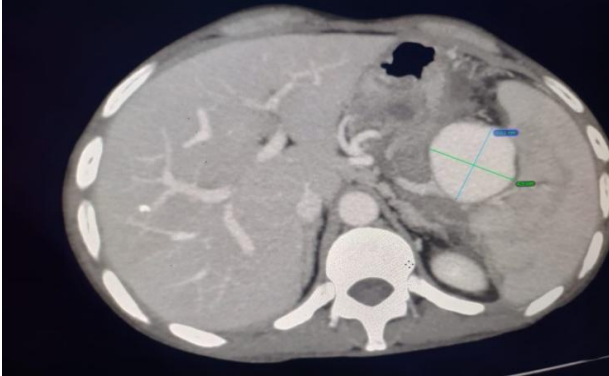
CT abdominal angiography showing pseudoaneurysm of splenic artery with features of chronic pancreatitis.
